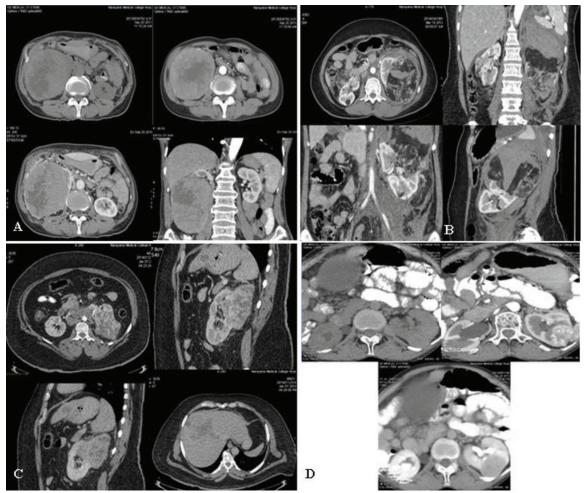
A. Renal Cell Carcinoma: Plain and Contrast enhanced computed tomogram (axial and coronal) No e/o Lymphadenopathy. T N M staging: T2, N0, M0- STAGE II. B. Angiomyolipoma With Hemorrhage: Contrast enhanced computed tomogram (axial and coronal). C. Metastases: Contrast enhanced computed tomography (axial and sagittal) showing the large well defined exophytic heterogeneously enhancing lesion with few non enhancing areas with in it, consistent with the necrosis. D. Oncocytoma: Plain and Contrast enhanced computed tomogram (axial).
